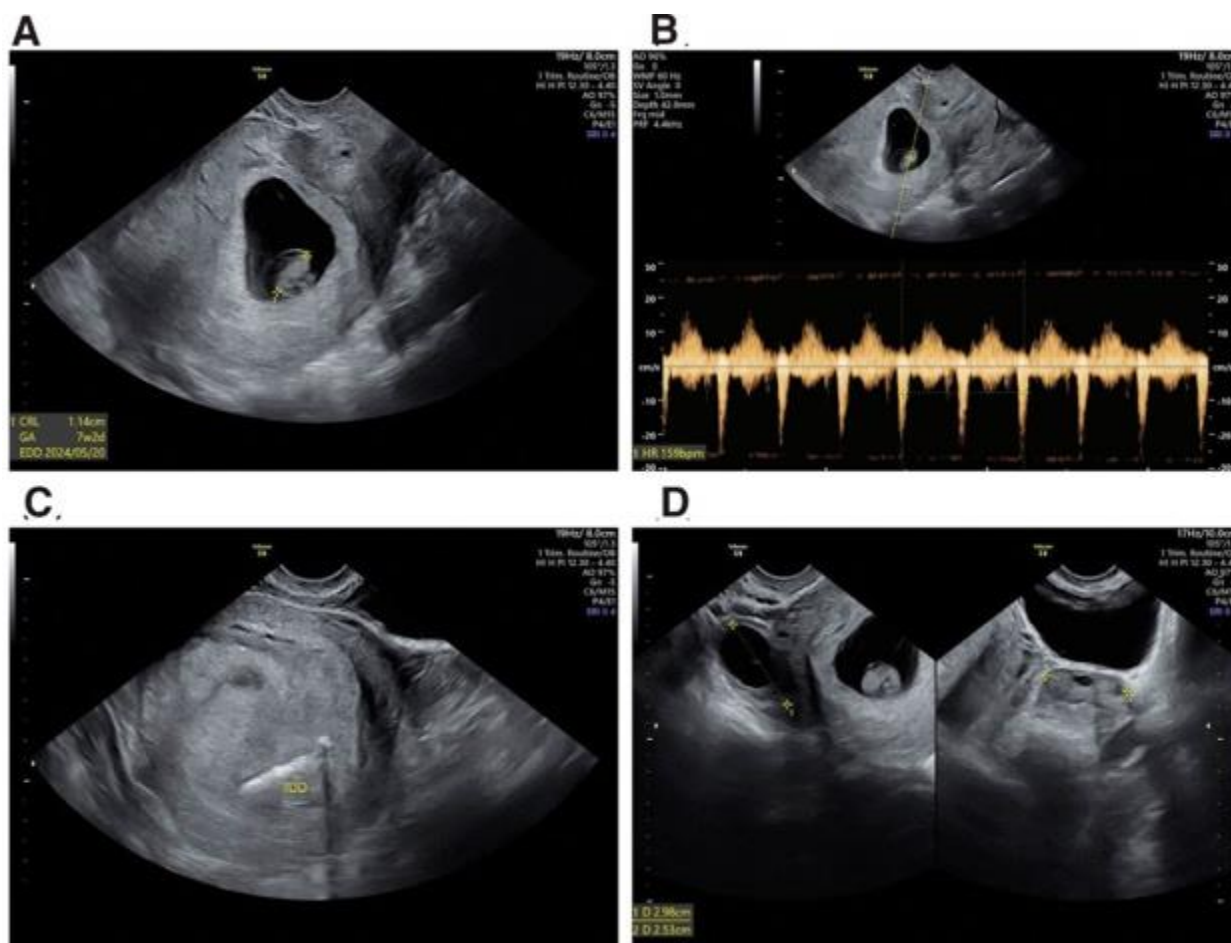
Transvaginal ultrasound showed the following in case of pregnancy with an IUD in place: (A) The length of the crown of the fetus was measured. (B) The fetal heartbeat recorded 159 beats per minute. (C) The IUD was detected in the placental region. (D) Bilateral adnexa presents a normal appearance. The diagnosis was of intrauterine pregnancy with an IUD in place and an impending miscarriage. [19]
